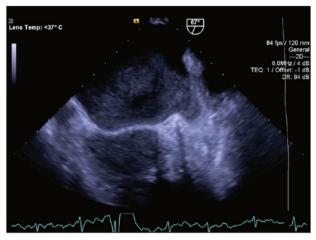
Transesophageal echocardiographic evaluation. See the presence of a thrombus in left atrial appendage.
